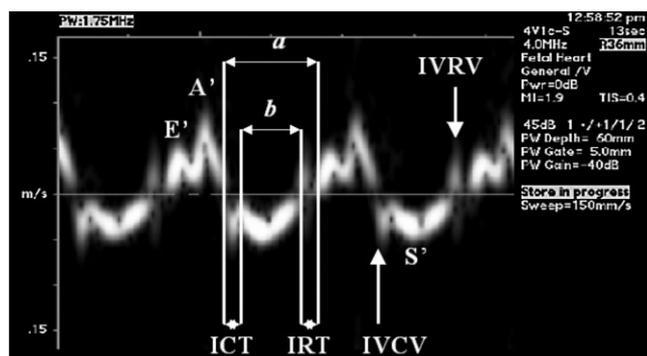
Right ventricular Tei index measurement using tissue Doppler-derived longitudinal myocardial wall motion velocities obtained at the tricuspid annulus. *A'*, myocardial lengthening velocity during the late ventricular filling (atrial contraction) phase of diastole; *a*, time interval from the end of the *A'* wave to the beginning of the *E'* wave; *b*, time interval from the beginning to the end of the *S'* wave; *E'*, myocardial lengthening velocity during early ventricular filling; ICT, isovolumic contraction time; IRT, isovolumic relaxation time; IVRV, isovolumic myocardial relaxation velocity; *S'*, myocardial shortening velocity during ventricular systole; Tei index = $(a - b)/b$.
